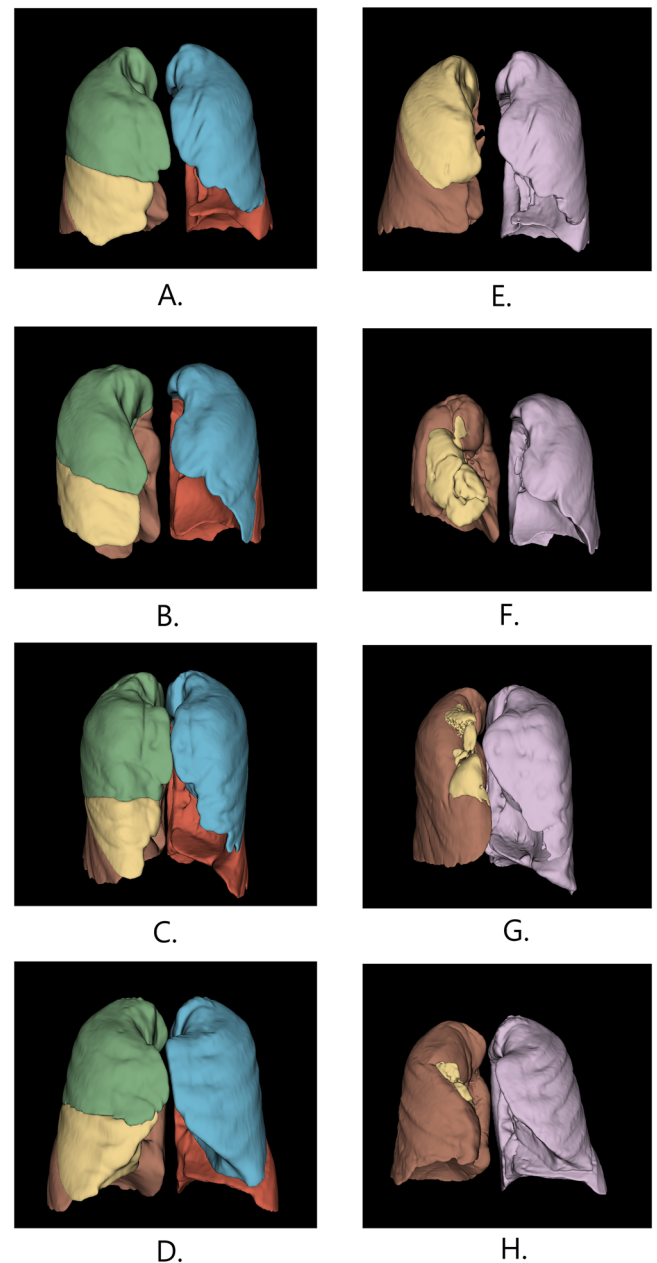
3D modelling of lobe segmentations of preoperative (left) and 6-month postoperative (right) CT scans in patients with increasing severity of postoperative atelectasis. The lobe in yellow in the right column depicts the progressively increasing grades of atelectasis: minimal (A, E), subsegmental (B, F), segmental (C, G), and lobar atelectasis (D, H). Lobe labels (colors): RUL (green), RML (yellow), RLL (brown), LUL (blue), LLL (red), LL (pink) (RUL right upper lobe, RLL right lower lobe, RML right middle lobe, LUL left upper lobe, LLL left lower lobe).
